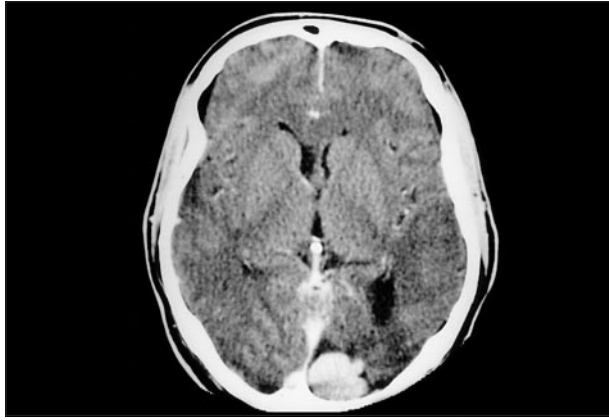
Cerebral computed tomographic scan showing a hyperdense lesion located in the left occipital area.
